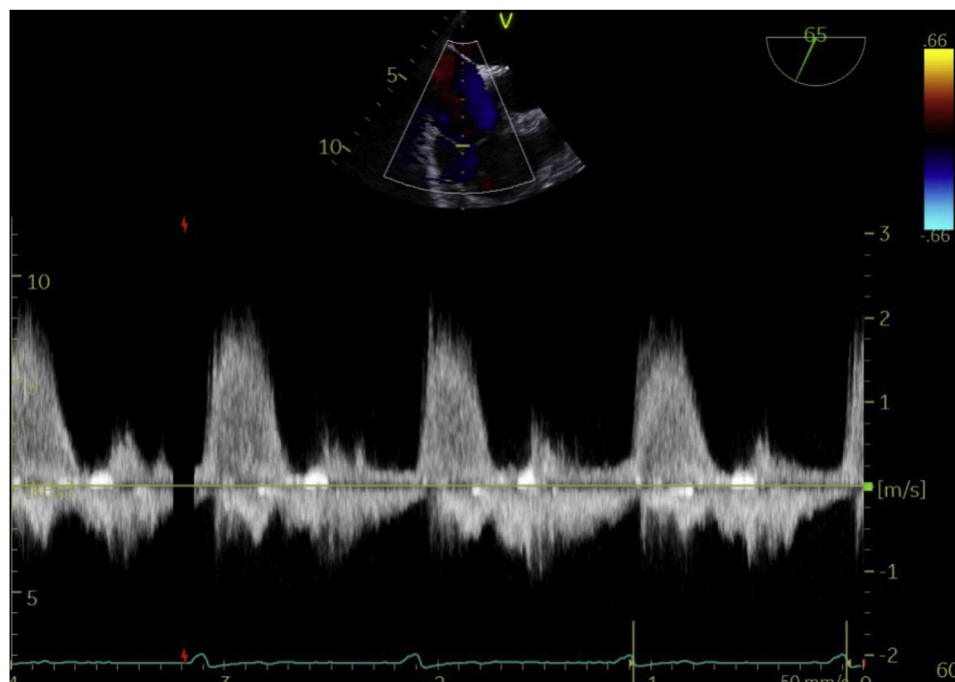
Continuous-wave Doppler of the TV showing a very dense profile and early peaking regurgitant jet consistent with severe TR.
